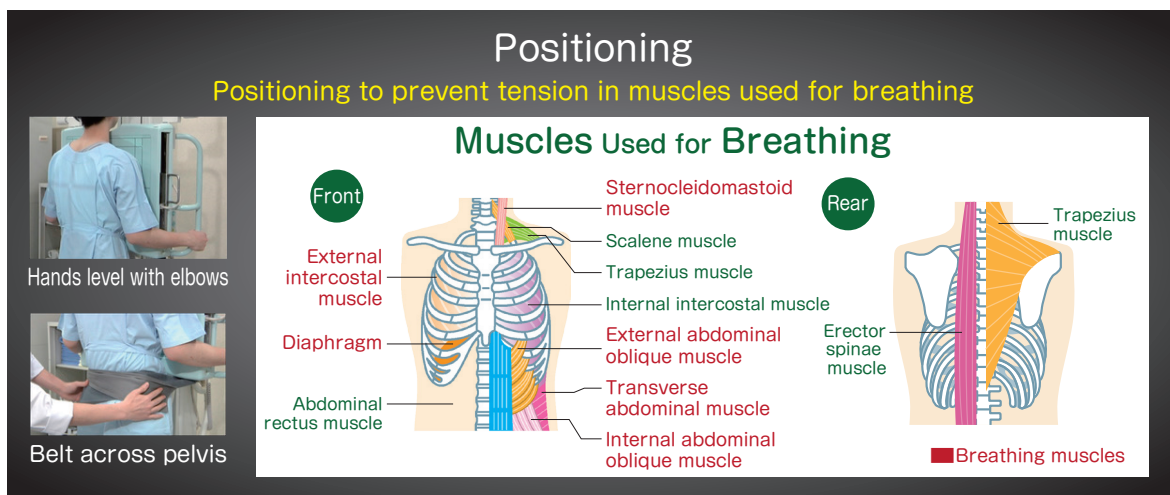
Positioning for Dynamic Chest Radiography
